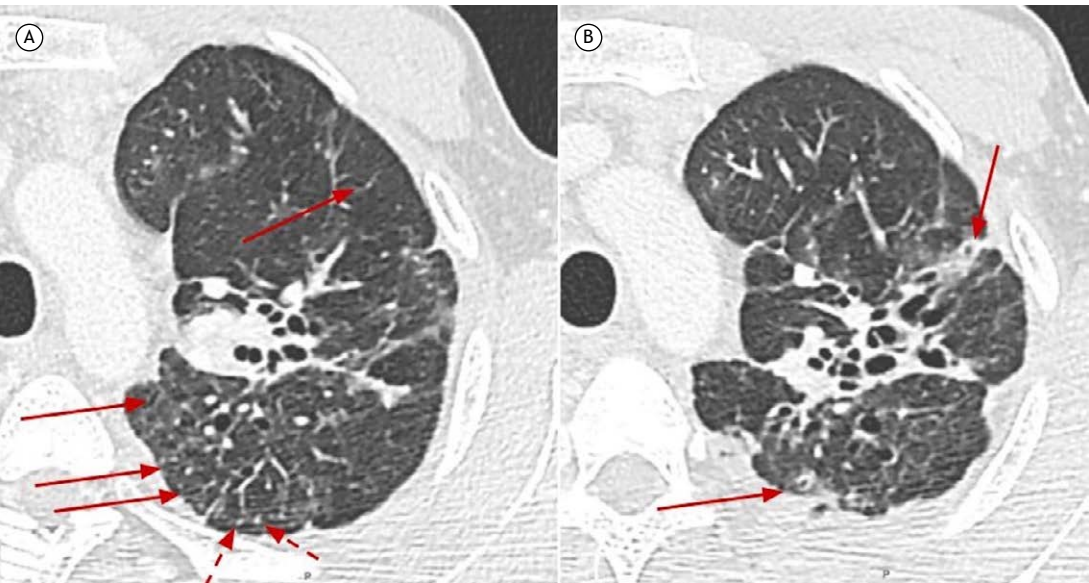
Axial CT scans with lung window settings of a male patient with multidrug-resistant tuberculosis and pulmonary fibrosis. In A, bronchiolectasis in the peripheral lung regions (arrows), in addition to centrilobular micronodules (dashed arrows) suggestive of dilated bronchioles with luminal content. In B, bronchiolectasis with thickened walls (arrows).
